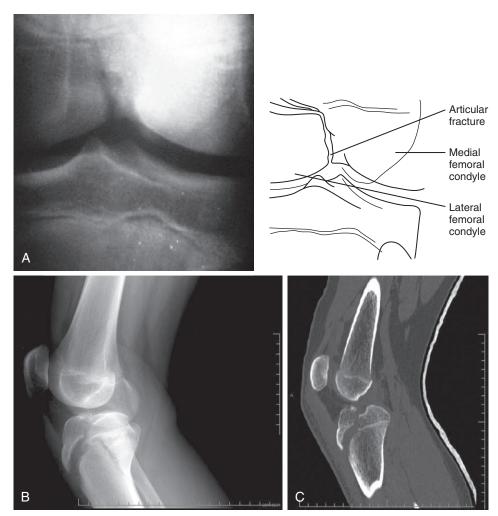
Articular fractures. A, This anteroposterior view of the knee demonstrates intraarticular extension of a fracture line that exits at the junction of the medial and lateral femoral condyles. The condyles are separated by only a few millimeters. This can also be termed an *intercondylar fracture*. B, On coming down from a rebound, a 14-year-old basketball player landed with a twist with his knee in extension. The lateral radiograph demonstrates intraarticular extension of a fracture line that starts at the tibial tubercle and exits in the middle of the knee joint. C, On computed tomography scan the degree of intraarticular displacement of the fracture is better appreciated.
